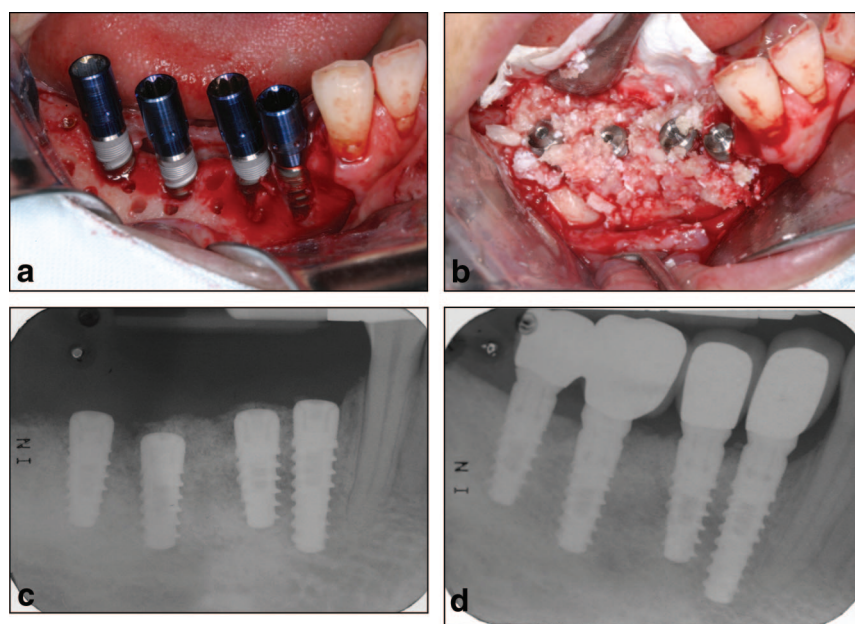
a, Clinical view of MIS implants in atrophic posterior mandibular area. b, Allograft and resorbable membrane were used for vertical ridge augmentation. c, Periapical radiograph at implant placement. d, Periapical radiograph taken 12 months after loading.
